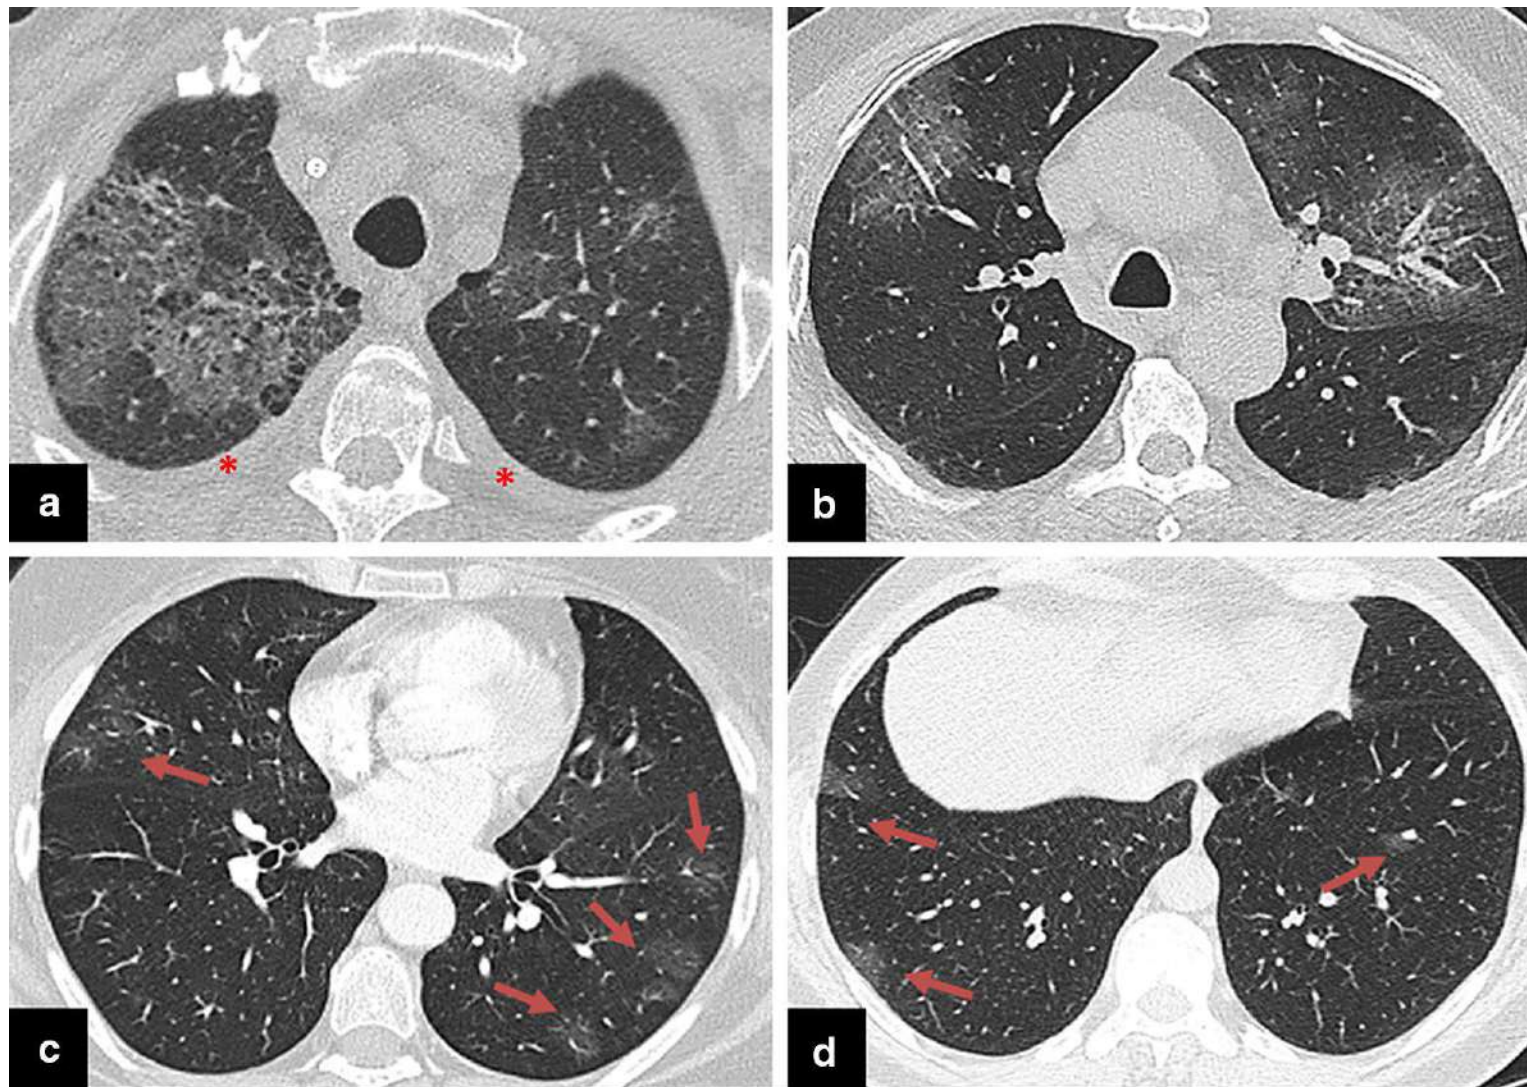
a–b Axial HRCT images of two patients with acute exacerbation of interstitial lung disease (ILD) show extensive bilateral ground-glass opacities and focal consolidations, superimposed to a background parenchymal pattern consistent with an underlying ILD compatible with non-specific interstitial pneumonia pattern (a) and with usual interstitial pneumonia pattern(b)
